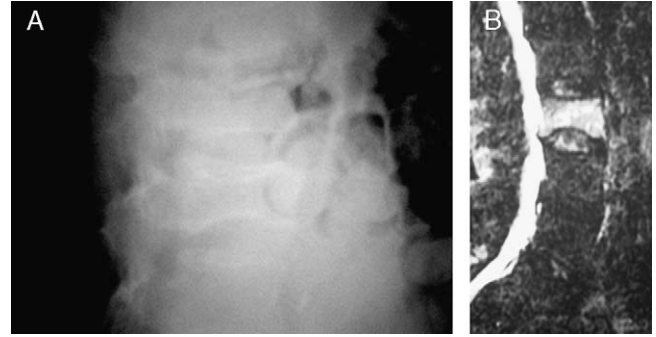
Preoperative imaging studies. A, Preoperative plain film. B, Preoperative magnetic resonance imaging.
